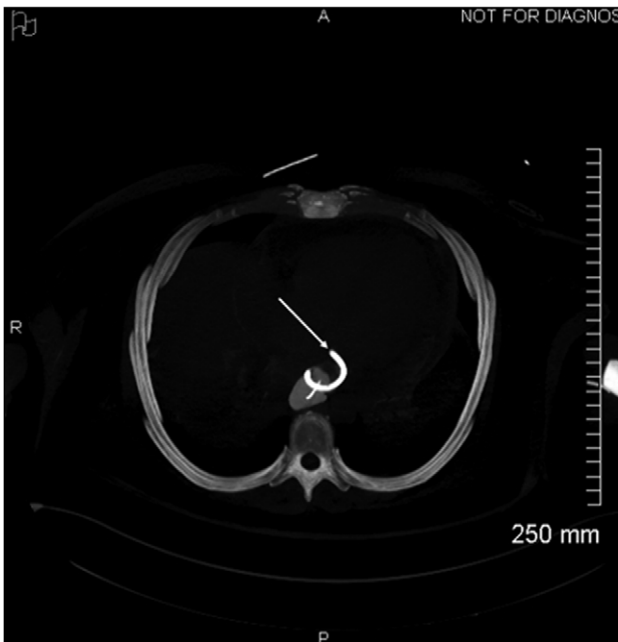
Axial view of opacification on CT showing the externalization of the drain in the pericardium (arrow).
